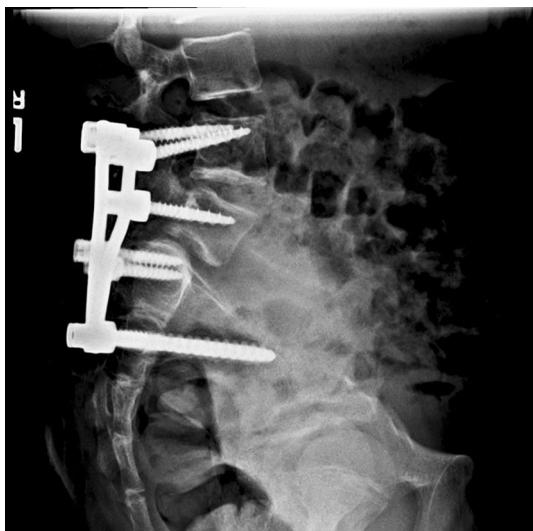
Lateral radiograph after index procedure. Reproduced with permission from the Children’s Orthopaedic Center, Los Angeles
